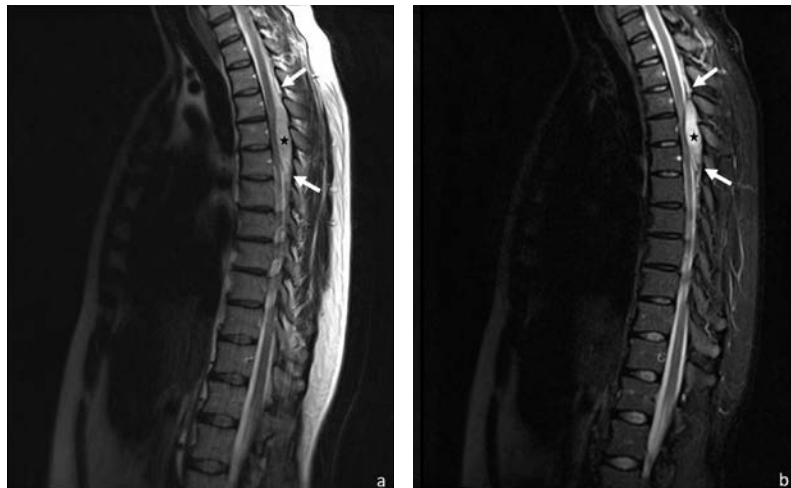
Sagittal T2-weighted (a) and corresponding Short Tau Inversion Recovery (STIR) (b) images through the thoracic spine.
